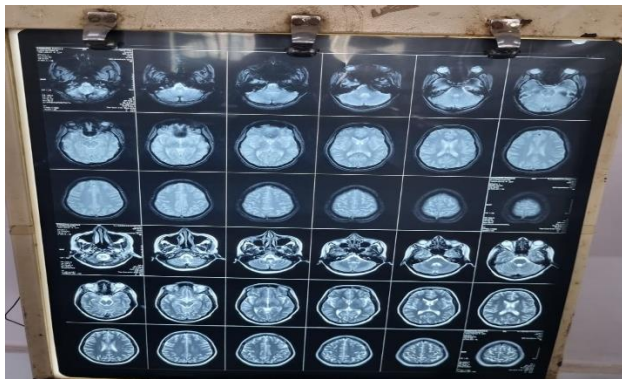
MRI brain showing altered signal intensity in posterior aspect of medulla oblongata appearing hyperintense on T2/T2 IR and isointense on T1 with partial diffusion restriction suggestive of demyelination versus acute infarct.
